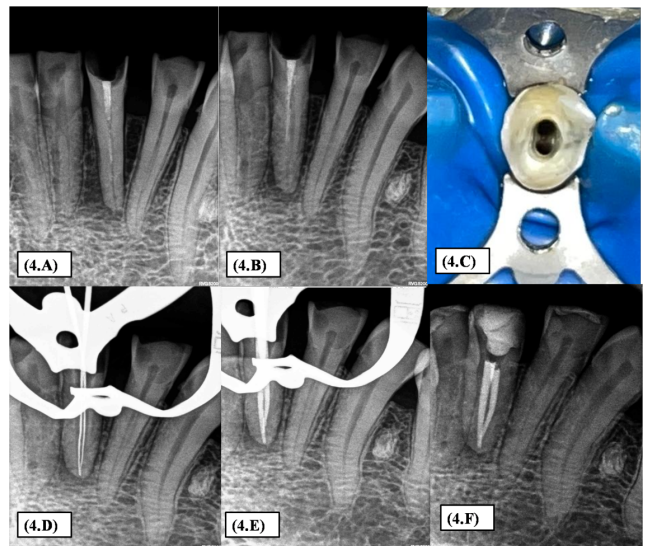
Case report 3: Missed canal in Mandibular central incisor (31); A: Pre-operative radiograph; B: Mesially angulated radiograph revealing the missed canal; C: Access cavity preparation; D: Working length determination; E: Master cone GP fit radiograph; F: Post-operative radiograph at 1 year follow-up
